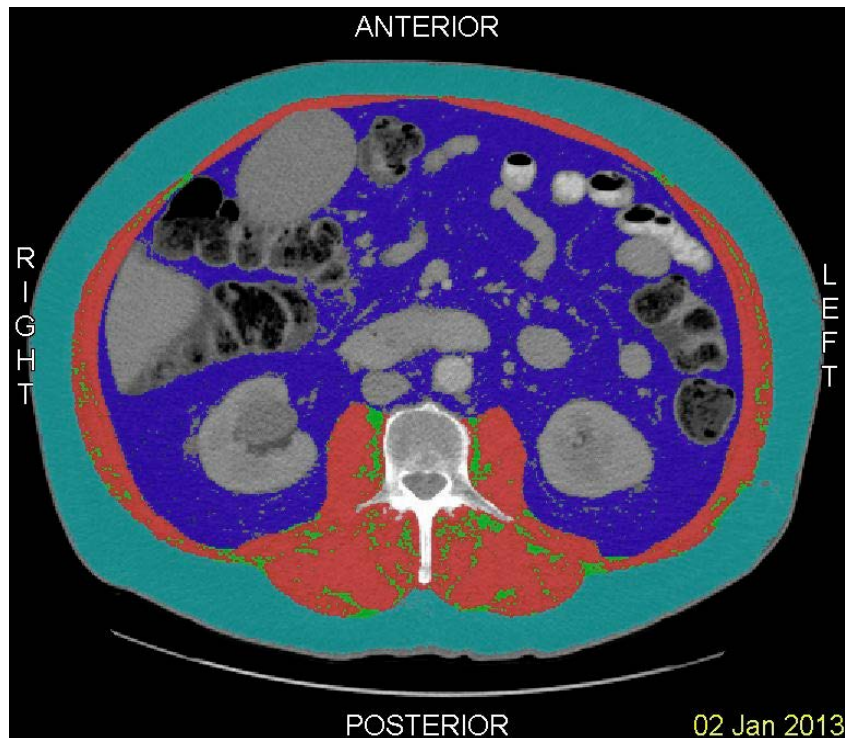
L3 vertebra CT image slice showing skeletal muscle cross sectional area (in red)
